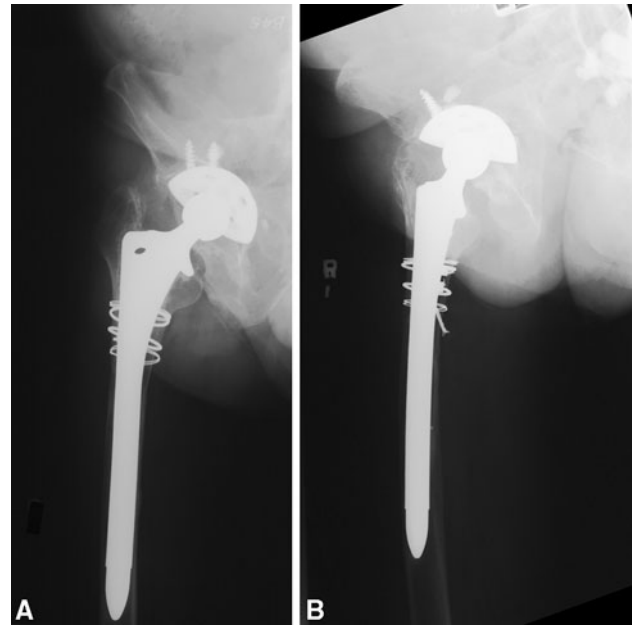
B (A) AP and (B) lateral radiographs show the result of cementless THA 3 years after revision.
